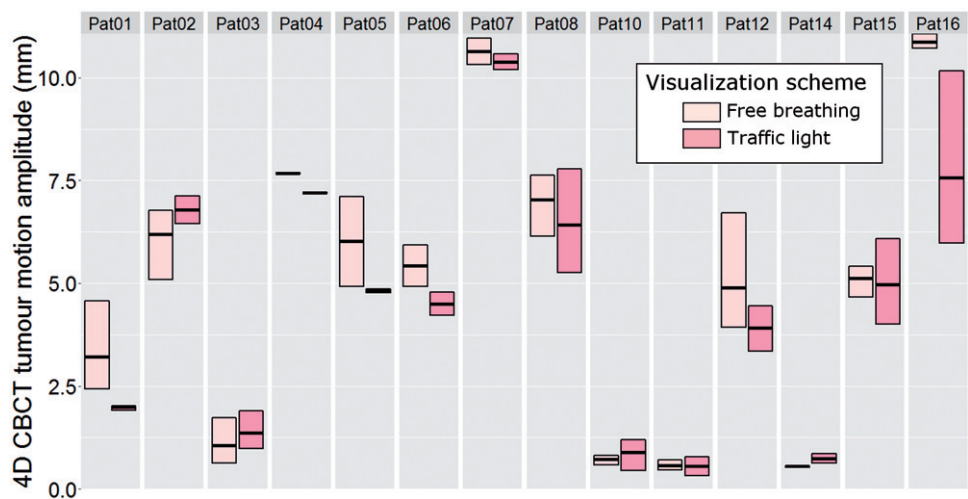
The minimum, mean and maximum tumor inferior-superior amplitudes measured with 4D CBCT for each patient with and without the visual feedback device. Note Pat04 attended only one session.
